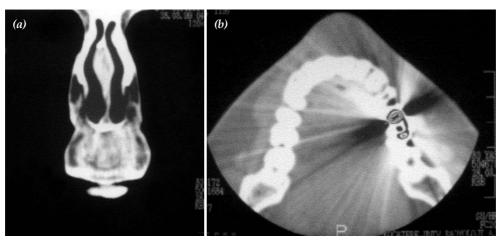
(a) A computed tomography scan in the coronal plane showing the lesion inside the upper lip. (b) An axial scan showing the tumor with clear margins.
